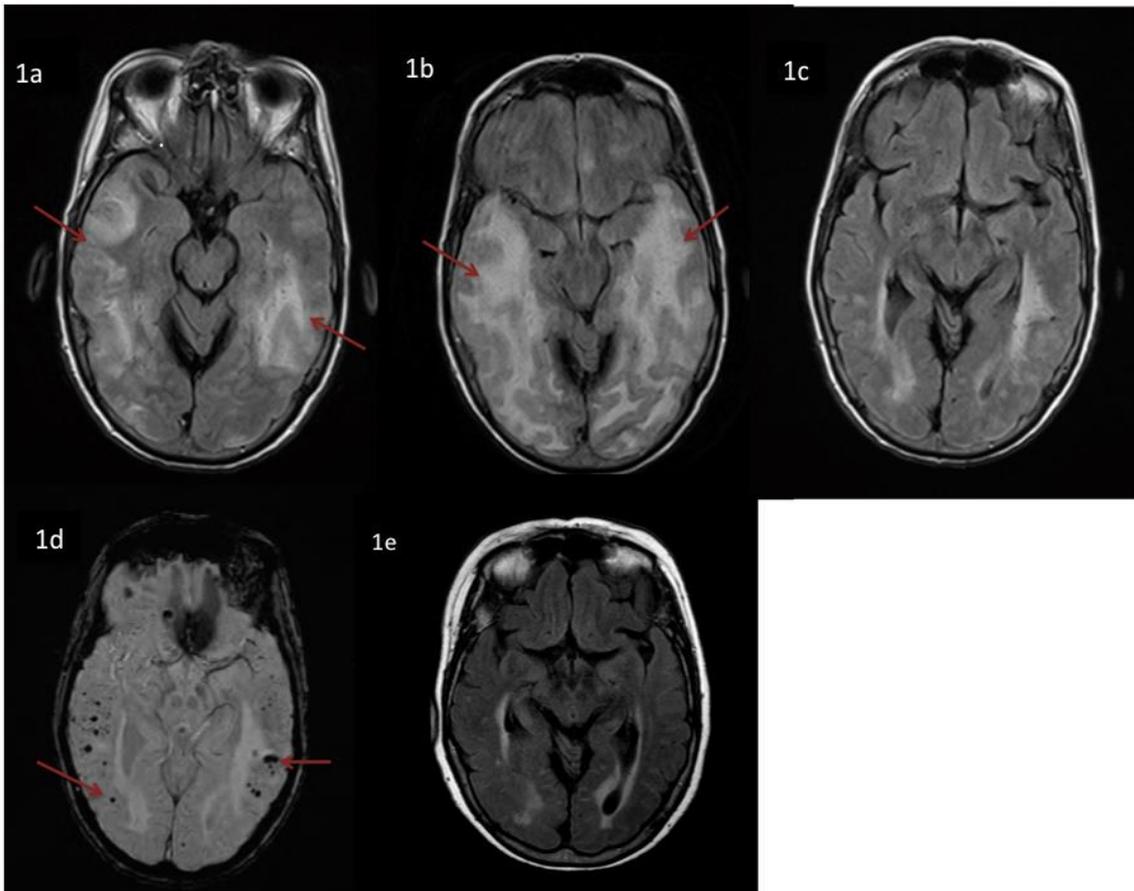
Axial T2 FLAIR MRI brain in December 2018 showing bi-temporal and parietal hyper-intensities.
